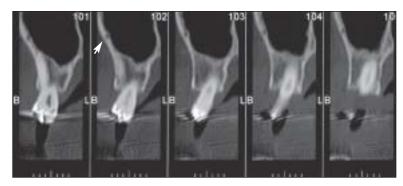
Transversal view of the CT scan of a left sinus in the middle third of the sinus cavity. On all views, the artery is inside the external wall. PSAA (arrow).
